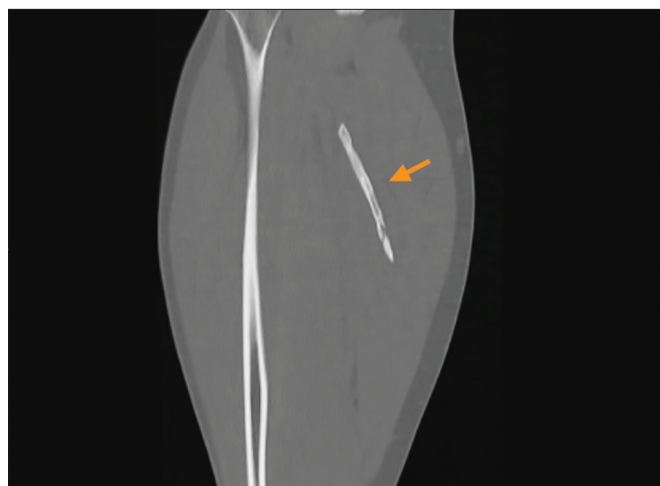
Coronal-view computed tomography image of the right lower leg demonstrating heterotopic ossification in the right soleus muscle (arrow). This courses along the myotendinous junction of the muscle.
